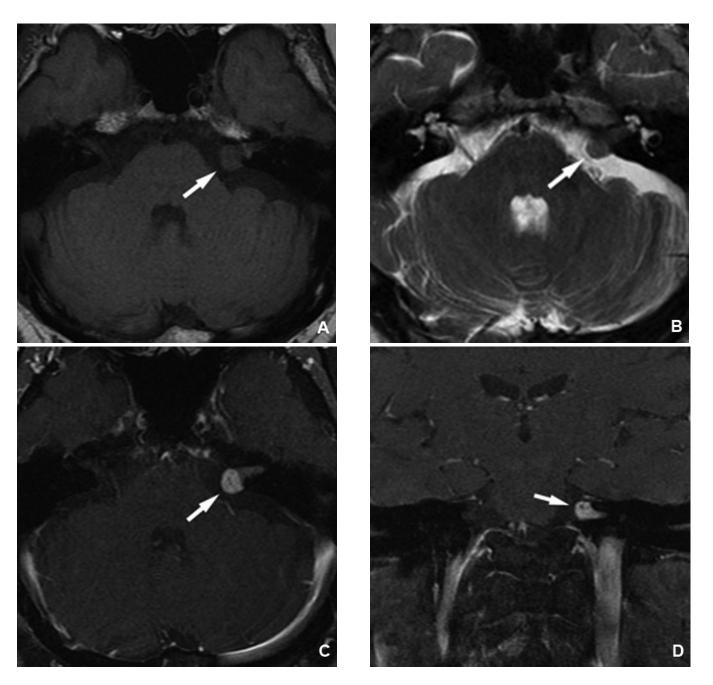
71-year-old man with asymmetric sensorineural hearing loss. Contrast-enhanced MRI of the brain and IACs. Axial precontrast T1- (A) and T2-weighted (B) images show an ice-cream-cone-shaped mass centered in the left porus acousticus that is isointense to brain parenchyma. Axial (C) and coronal (D) postcontrast fat-suppressed T1-weighted images show avid enhancement of the lesion, without evidence of a dural tail. The findings are characteristic of a vestibular schwannoma (white arrows).
